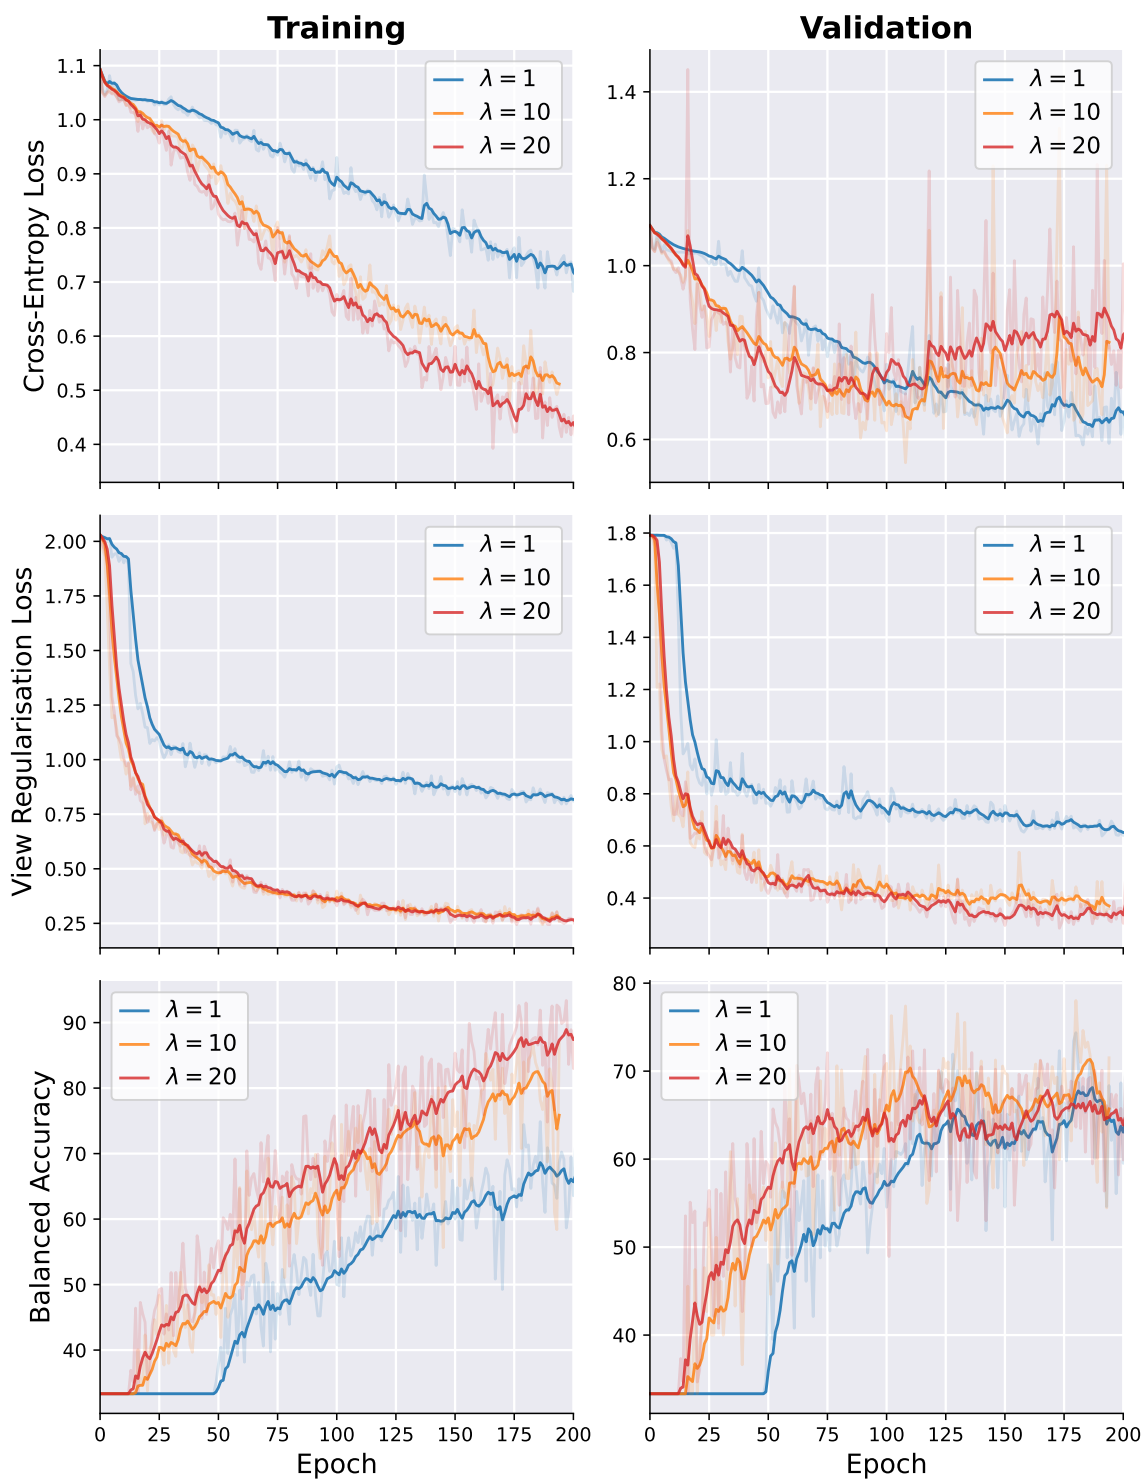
Training and validation performance of the fully convolutional transformer feature extractor multiple instance learning model with varying view regularisation strengths on split 3 of the Tufts Medical Echocardiogram Dataset. Cross-entropy loss, view regularisation loss, and balanced accuracy are shown from top to bottom. The left column presents the results for the training set, while the right column shows the results for the validation set. Smoothing was applied to the raw output values (seen in matching transparent colors) to help visualisation.
